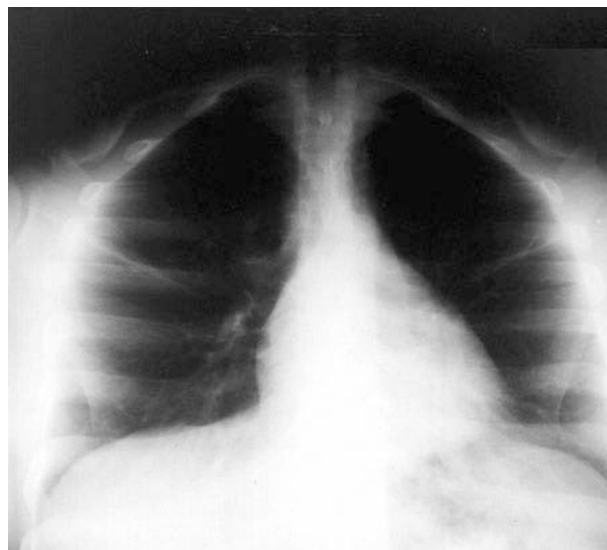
AP lordotic chest radiograph.
